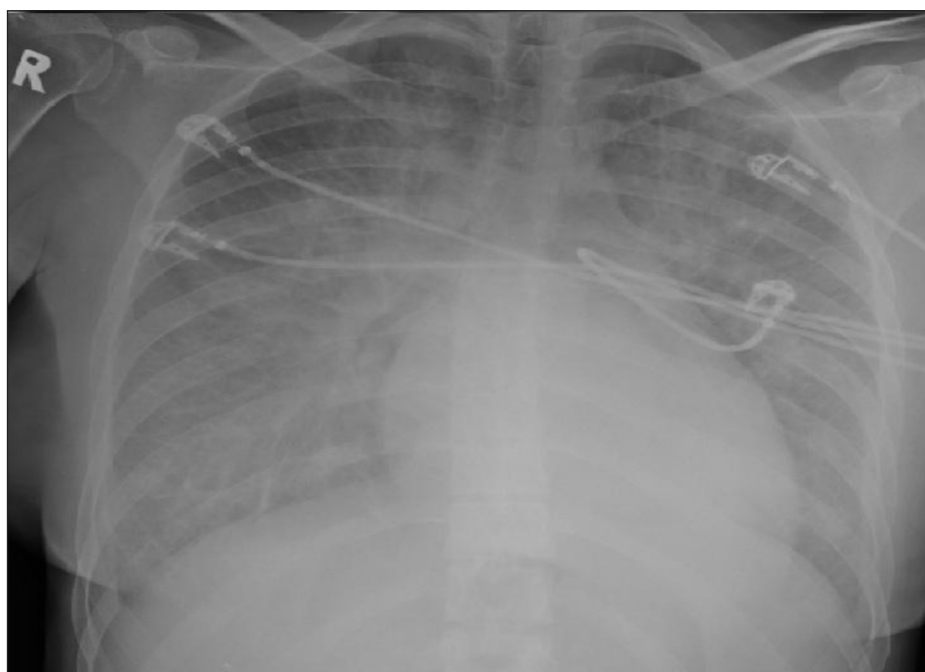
Chest radiograph demonstrating pulmonary oedema and pleural effusions
